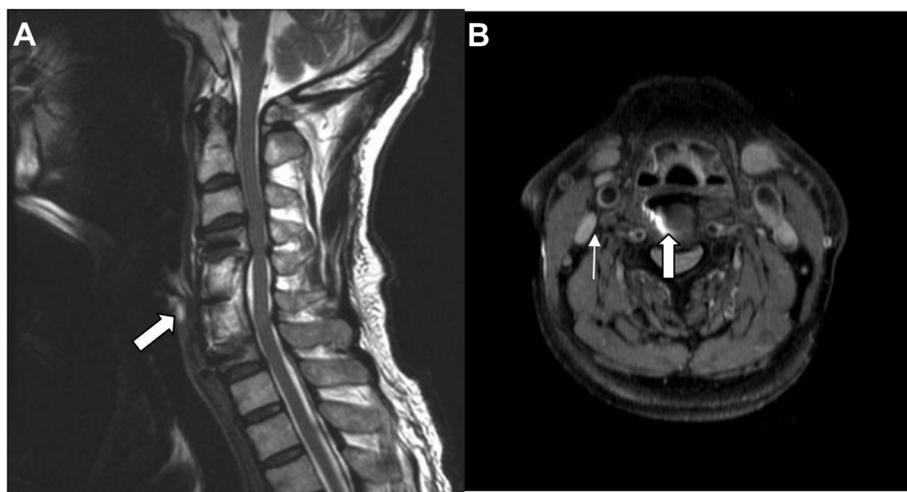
(A) Sagittal T2-weighted magnetic resonance image of the cervical spine showing the C5–6 spondylodiscitis and epidural abscess (thick arrow) causing spinal canal stenosis. (B) Transverse T2-weighted magnetic resonance image of the cervical spine showing right jugular vein thrombosis (thin arrow) and C6 spondylodiscitis (thick arrow).
